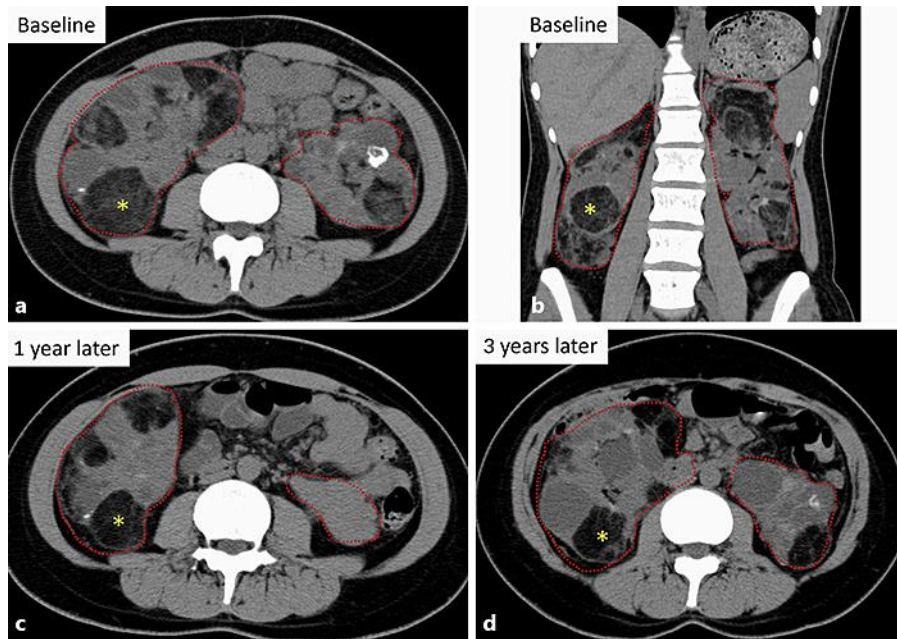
Case 3. a, b Computed tomography (CT) reveals huge RAMLs before initiation of everolimus therapy. The maximum diameter of the biggest RAML (asterisk) is 12.7 cm. c CT shows huge RAMLs at 1 year after initiation of everolimus therapy. The maximum diameter of the biggest RAML (asterisk) is 11.5 cm. d CT shows huge RAMLs at 3 years after initiation of everolimus therapy. The maximum diameter of the biggest RAML (asterisk) is 12.1 cm.
